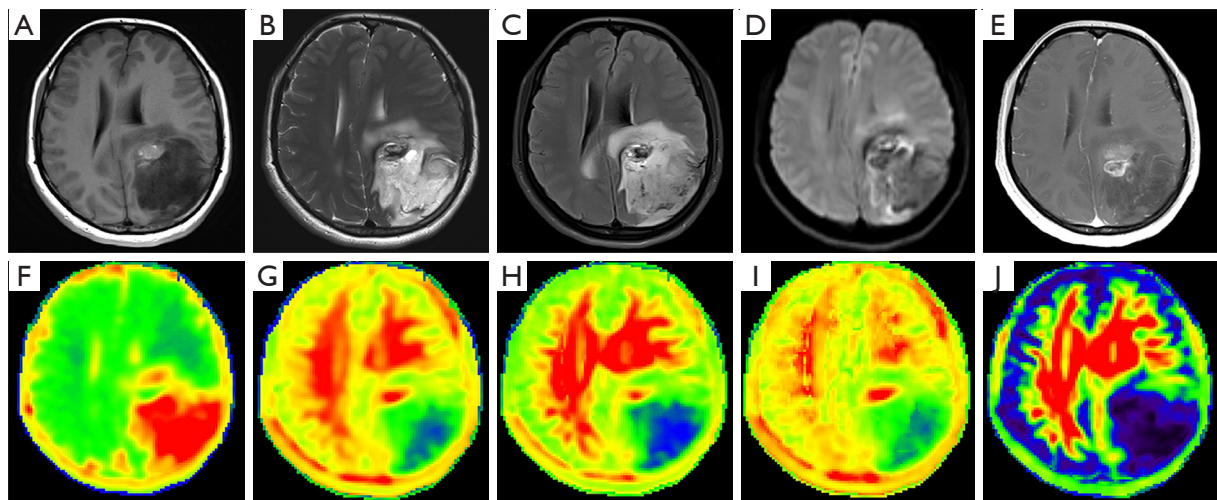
A 42-year-old female with HGG in the left parieto-occipital lobe (grade 3, Ki-67 = 10%). (A) The mass is hypointense and nodular-like hyperintense on T1WI, with an unclear boundary. (B,C) The mass shows mixed signal intensities on T2WI and FLAIR, accompanied by peritumoral edema and involving the cortex. (D) The mass shows punctate and striated hyperintensity on DKI ($b=1,000 \text{ s/mm}^2$). (E) Contrast-enhanced T1WI of the mass shows marked inhomogeneous enhancement. (F) MD map; (G) MK map; (H) Kr map; (I) Ka map; (J) FA map. HGG, high-grade glioma; T1WI, T1-weighted imaging; T2WI, T2-weighted imaging; FLAIR, fluid-attenuated inversion recovery; DKI, diffusion kurtosis imaging; MD, mean diffusivity; MK, mean kurtosis; Kr, radial kurtosis; Ka, axial kurtosis; FA, fractional anisotropy.
